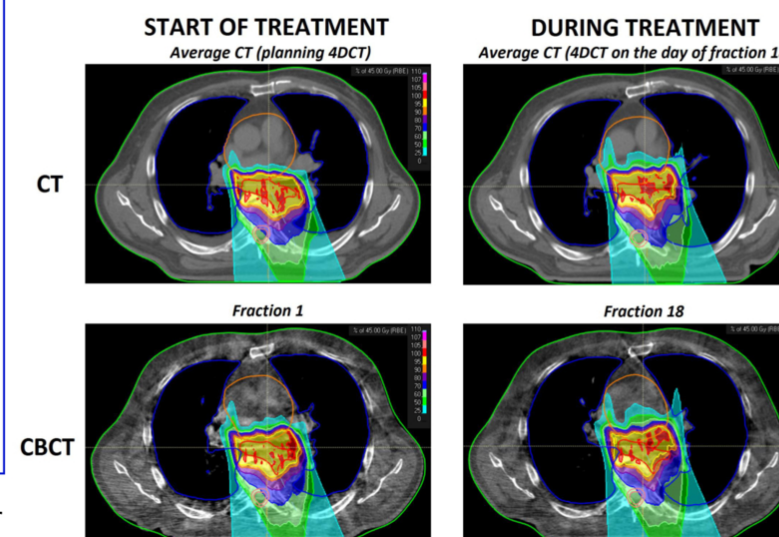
Isodoses of CT- and CBCT-based PT dose calculation at start and mid-treatment for patient 1
